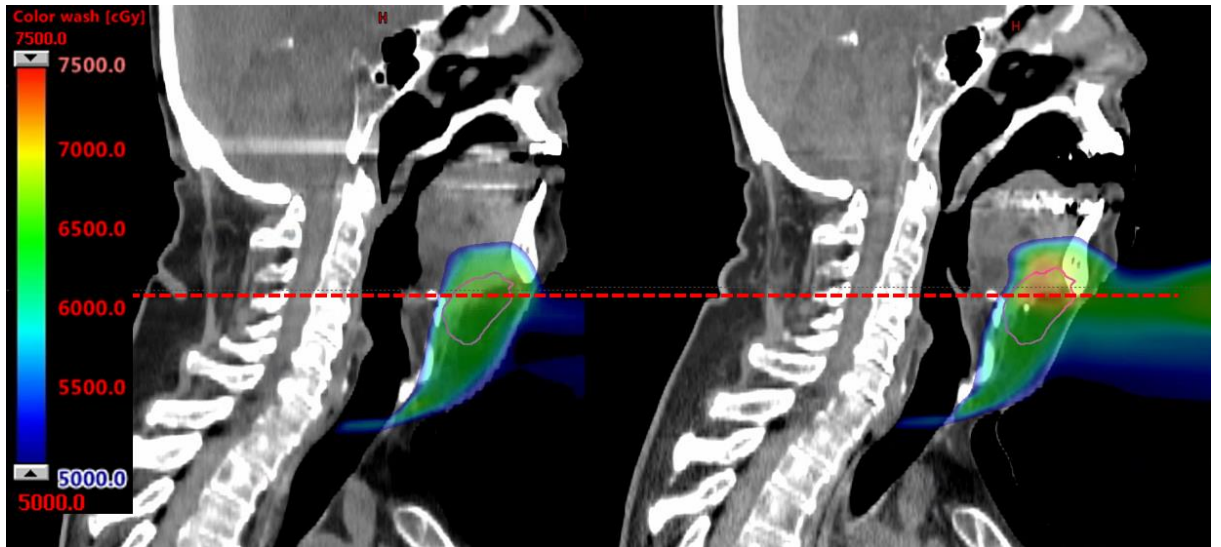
Sagittal view of the planning CT for patient 6. CTV1 contour and corresponding slice of the first vCT-calculated nominal plan are shown.
